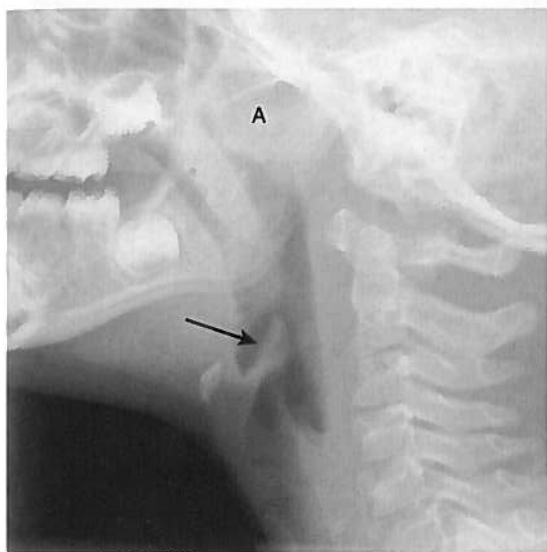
Normal epiglottis. Lateral radiograph showing thick-appearing epiglottis (arrow). Incidentally, note appearance of enlarged adenoid tonsils (A).
